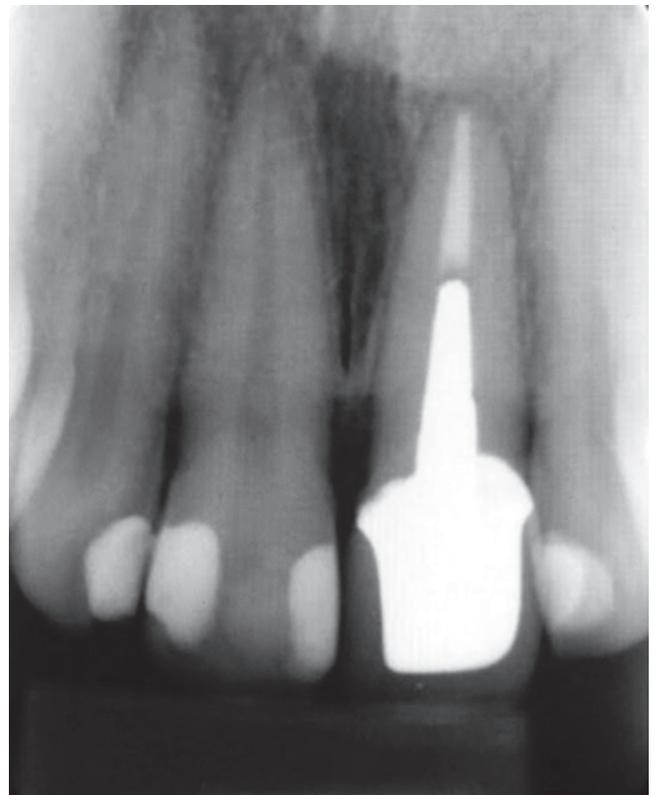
Radiograph showing the NMF installed in the root canal.
